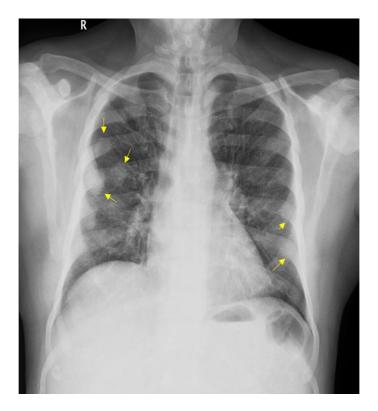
X-ray chest PA view showing multiple dense opacities on both sides (Yellow arrows).
